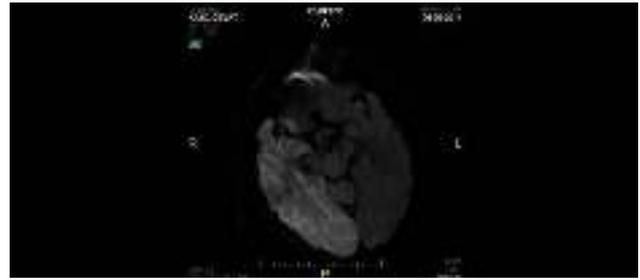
Diffusion weighted MRI-2
